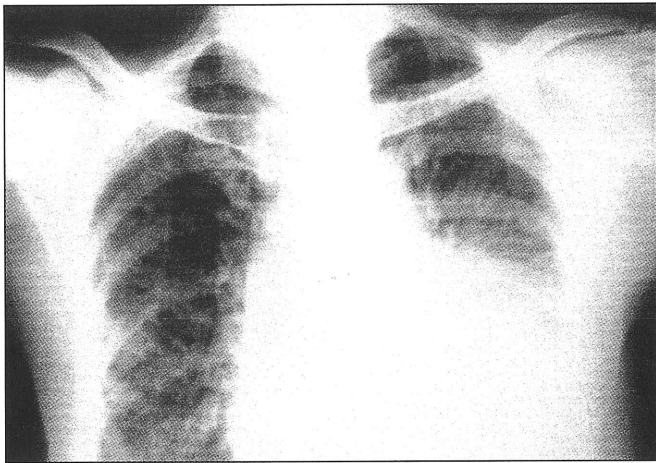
Posteroanterior chest x-ray showing bilateral miliary pattern and left-sided pleural effusion (A). Chest CT showing a 7x8cm mass lying posterolaterally and pleural effusion on left side and diffuse reticulonodular infiltration in a miliary pattern (B).
